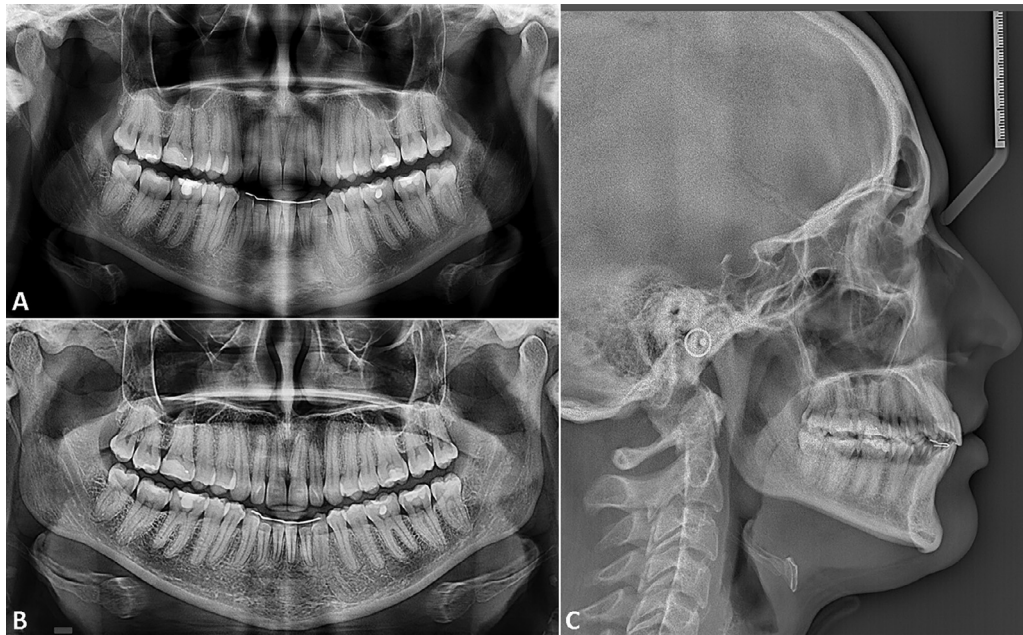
A, Posttreatment panoramic radiograph; B and C, Posttreatment panoramic and lateral cephalometric radiographs after 3-year retention.
